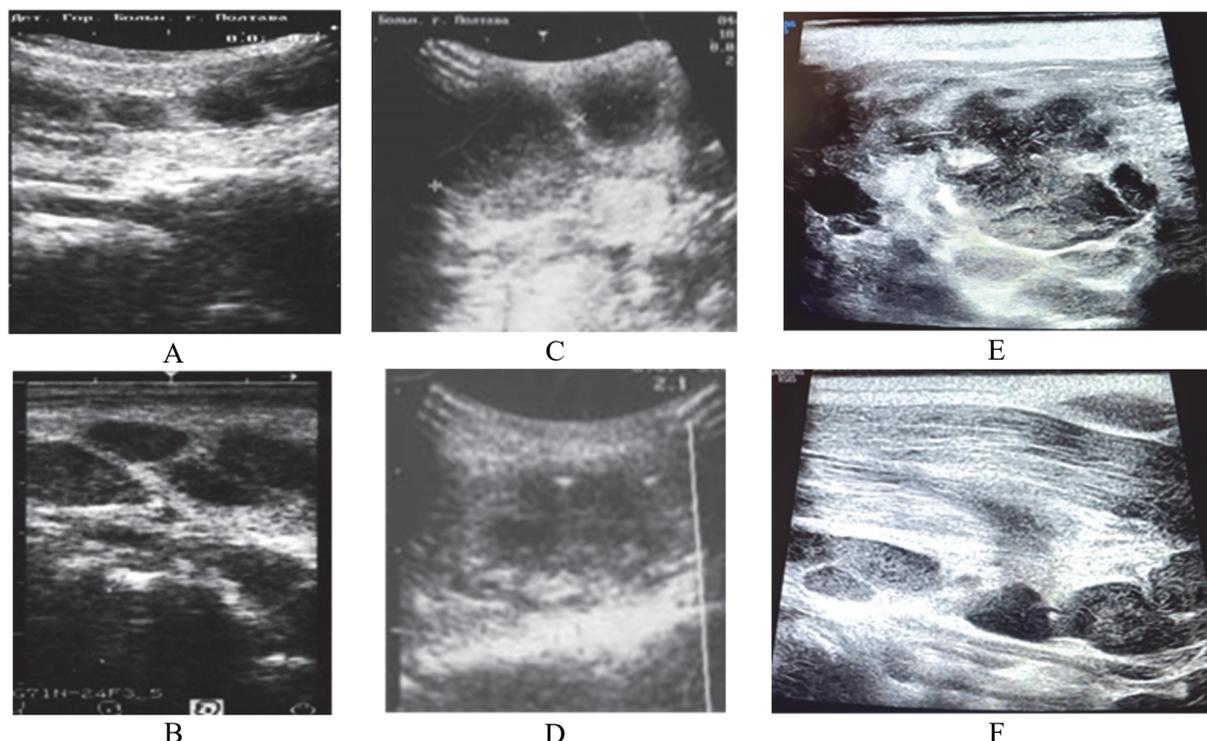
Ultrasound results of patients with acute serous lymphadenitis (A, B), acute purulent lymphadenitis (C, D), and adenophlegmon of the neck (E, F). A – lateral surface of the neck on the left (hypoechoic areas of ovoid shape with clear boundaries up to 1.5 cm in diameter, limited by echogenic surrounding tissues); B – right parotid-masticatory area (subcapsular – four lymph nodes with hypoechoic structure, different in size, with clear contours). C, D – enlarged lymph nodes with anechoic and hypoechoic structures. E – non-contoured purulent focus with no clear structure; F – reactively enlarged adjacent lymph nodes of varying echogenicity with clear boundaries, compaction of adjacent soft tissues of the neck).
